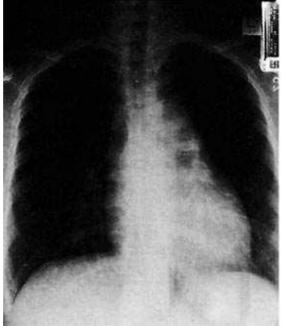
Chest X-ray of a large mediastinal mass that is due to Hodgkin's lymphoma.
